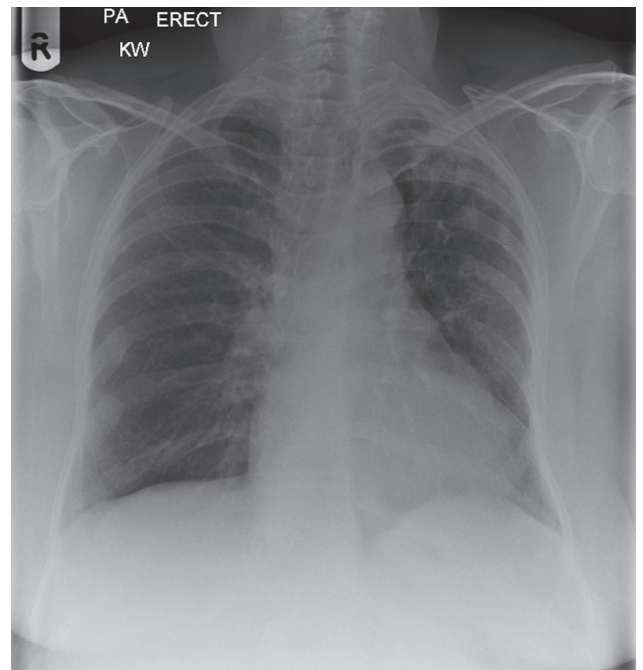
Chest X-ray after completion of treatment
